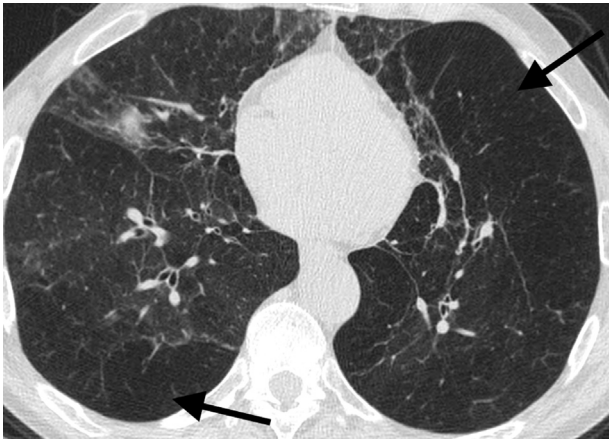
Methylphenidate (Ritalin) abuse. Axial CT in lung window shows emphysema with diffuse areas of low attenuation throughout the lungs with a paucity of vessels (arrows).
